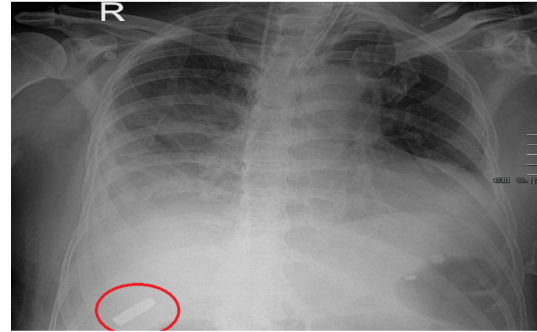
Chest X-ray of patient
